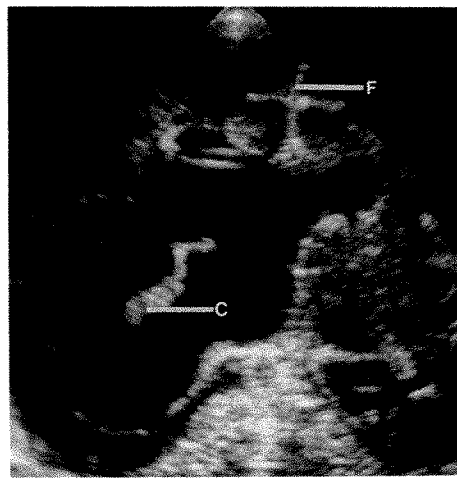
Neonatal cranial sonogram in coronal plane in a 2-day-old neonate confirms unilateral dilatation of right lateral ventricle and shows slight leftward shift of medial right ventricular wall. F = interhemispheric fissure, C = choroid plexus.
